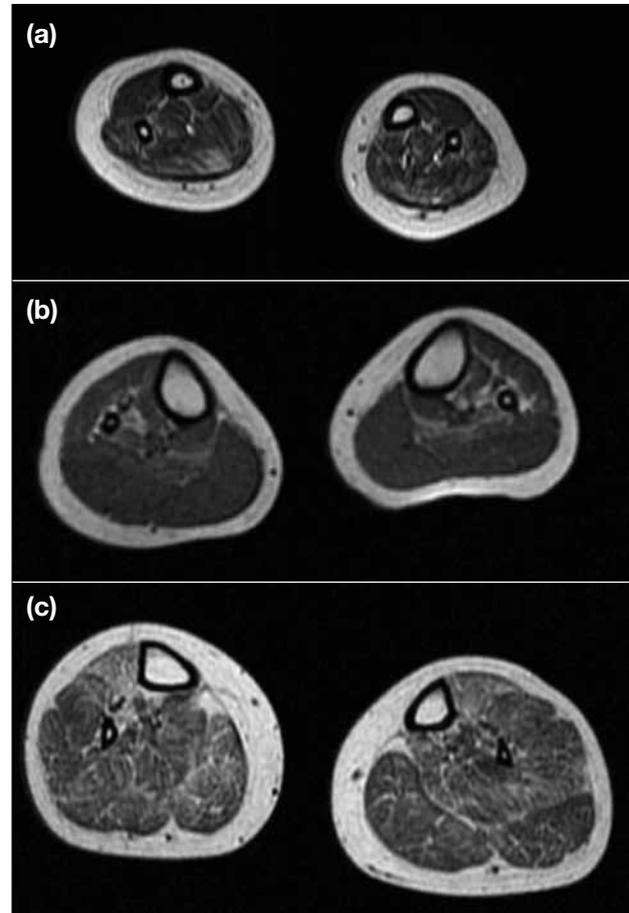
Axial T1-weight magnetic resonance images of the calf. (a) Patient 1: there is selective involvement of soleus and tibialis posterior, with relative sparing of tibialis anterior. (b) Patient 2: there is mild fat infiltration of bilateral soleus, peroneal and tibialis posterior. No definite fat infiltration of the tibialis anterior, gastrocnemius medialis and gastrocnemius lateralis is noted. (c) Patient 3: the tibialis anterior and tibialis posterior are more severely involved than the rest of the calf muscles.
